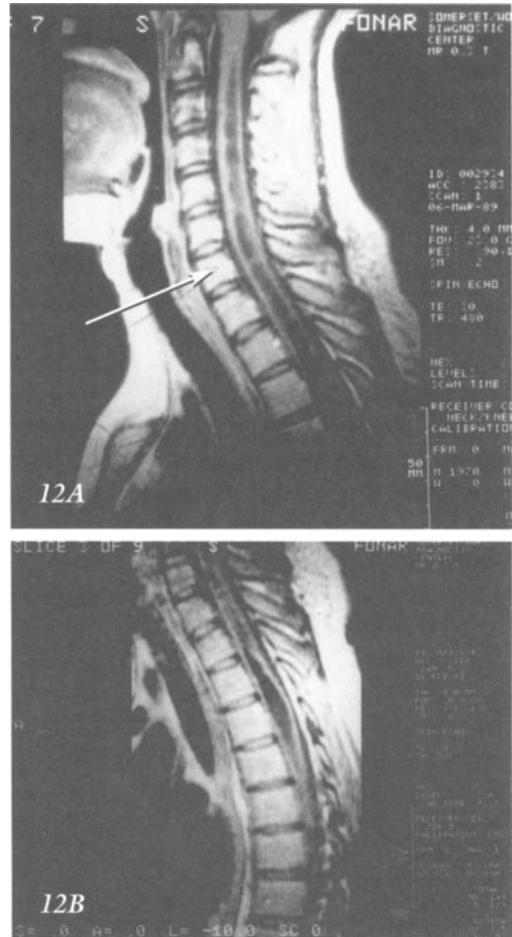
Syringomyelia. Case 9-5 MRI Scan. A) Cervical 2-Thoracic 5: Sagittal Section 10mm to left of midline-the arrow is on the cervical 7 vertebral body. B) Cervical 6- Thoracic 9: Sagittal section 10 mm right of the midline. The point of widest enlargement of the spinal cord is opposite the T4 vertebral body.
